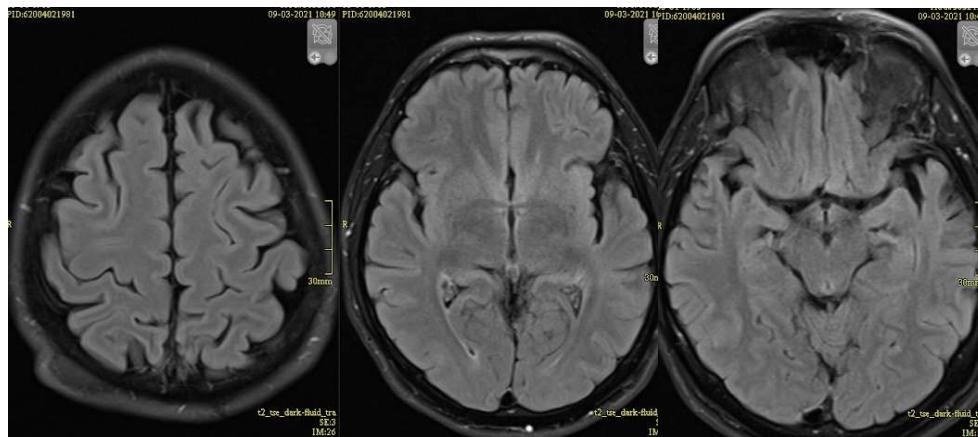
MRI Findings (2021): Initial Atrophic Changes in the Left Temporal Lobe
